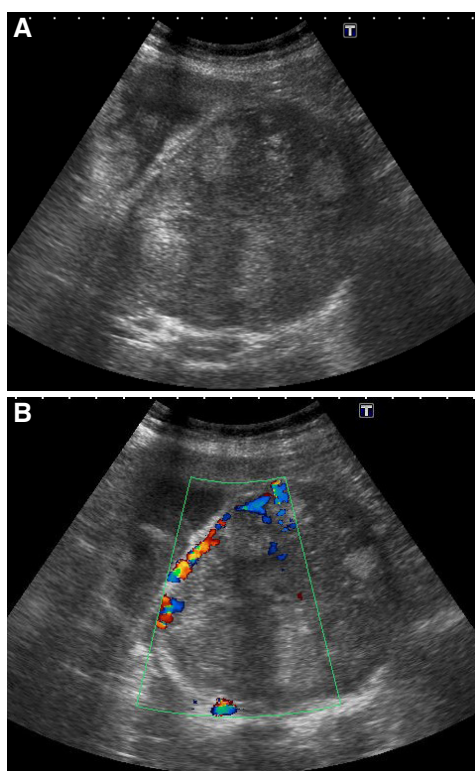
(A) Abdominal ultrasound B-mode showing large heterogeneous mass with hyper- and hypoechoic areas is observed in right hepatic lobe. Peritumoral vascular flow is demonstrated by Doppler (B)
